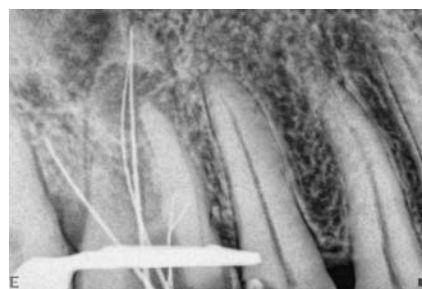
Working length confirmed using periapical radiograph.
